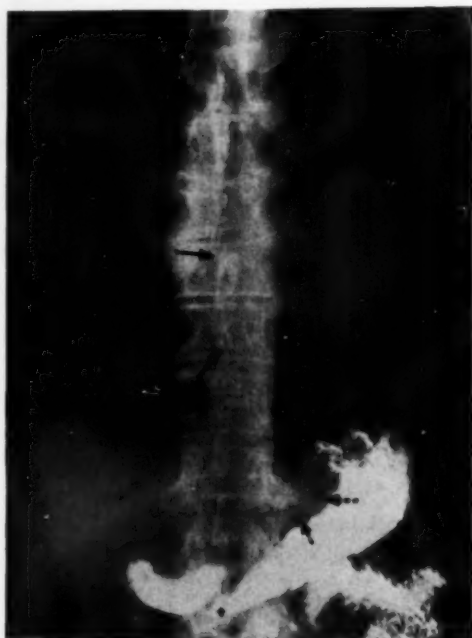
Paracardial lymph nodes. A 68-year-old white male had complained of dysphagia for one week. Roentgen examination disclosed an irregular, constricting lesion in the fourth segment of the esophagus, extending downward for a distance of 6 cm. This is best seen (solid arrows) in the erect right anterior oblique roentgenogram (A). Because of a prior and unrelated laryngeal tumor, there was some spillage over of the barium into the tracheobronchial tree. On a right anterior oblique projection taken in the prone position (B) enlarged paracardial lymph nodes are visible, indenting the stomach in the region of the cardia (dotted arrows).
